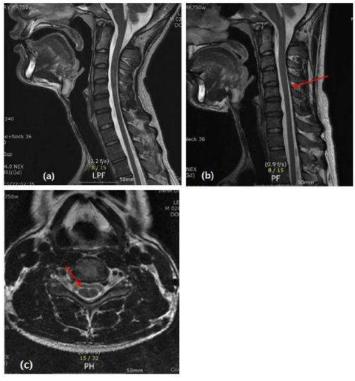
Cervical spinal cord MRI in neck flexion position showed minimal posterior dural detachment at C4, 5, 6 levels. (a) extension position on T2-weighted image, (b) flexion position on T2-weighted image, (c) Axial T2-weighted image shows mild flattening of spinal cord from C6-7 level on flexion position
